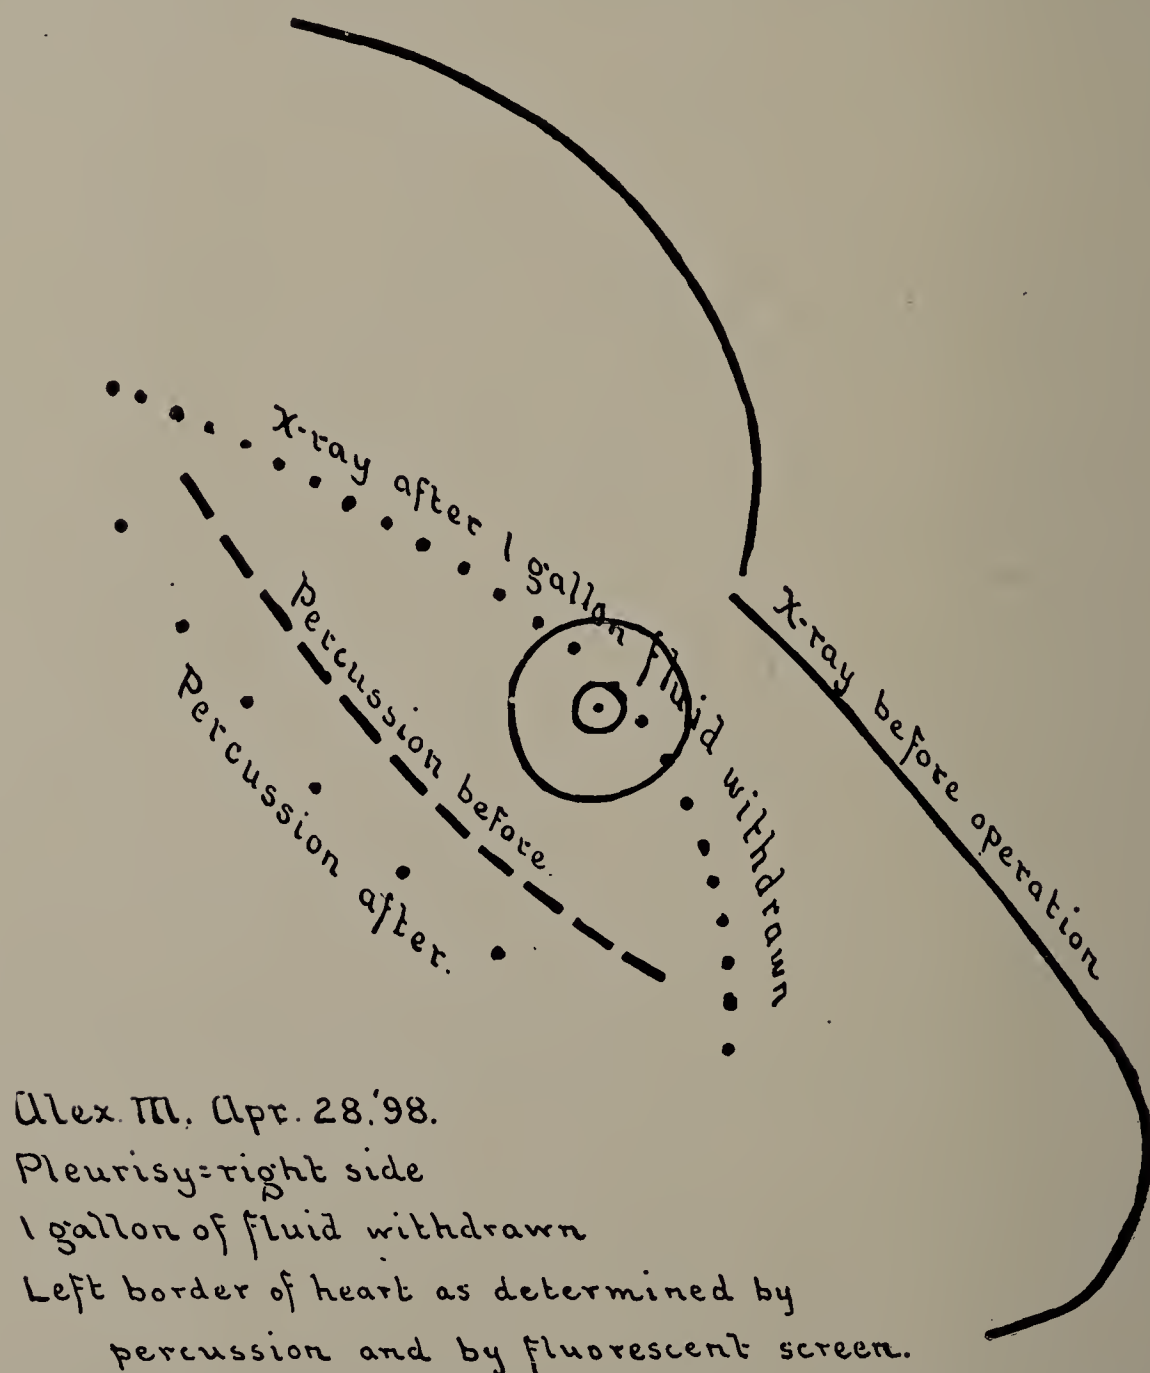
Alex. M. Cut shows the difference in the position of the left border of the heart as determined by the X-rays and by percussion both before and after operation. (Cut one-third life size.)
